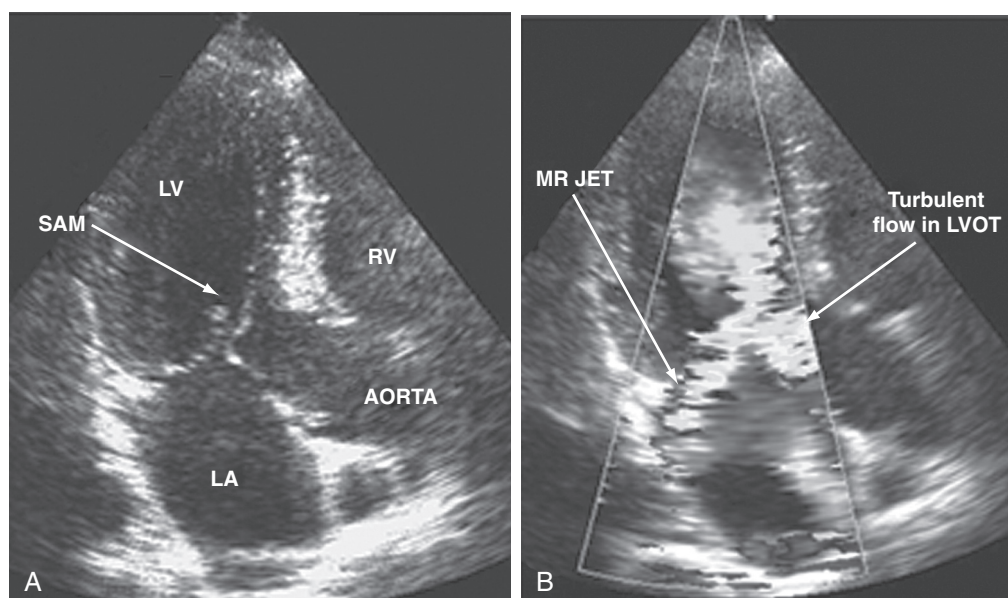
■ Systolic anterior motion (SAM) of the mitral valve in a patient with asymmetric left ventricular hypertrophy and dehydration. Two-dimensional transthoracic apical long-axis view shows movement of the anterior leaflet of the mitral valve (arrow) toward the interventricular septum during systole (A). This creates a subaortic dynamic obstruction. The resulting high velocity and turbulence in the left ventricular outflow tract (LVOT) gives a “mosaic” pattern of flow on color Doppler (B). A variable degree of asymmetric mitral regurgitation (MR) also may be present secondary to the systolic anterior motion, as shown in this example. LA, left atrium; LV, left ventricle; RV, right ventricle.
